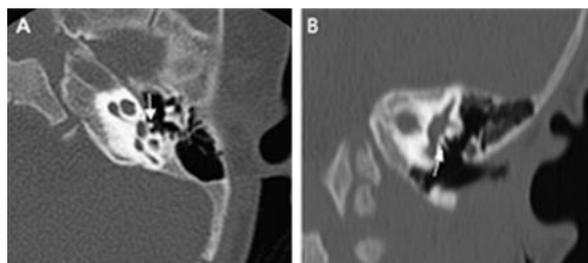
monopod stapes. (a) axial slice and (b) coronal reformat section of tempo CT scan left ear which shows single stapes called as monopod stapes
